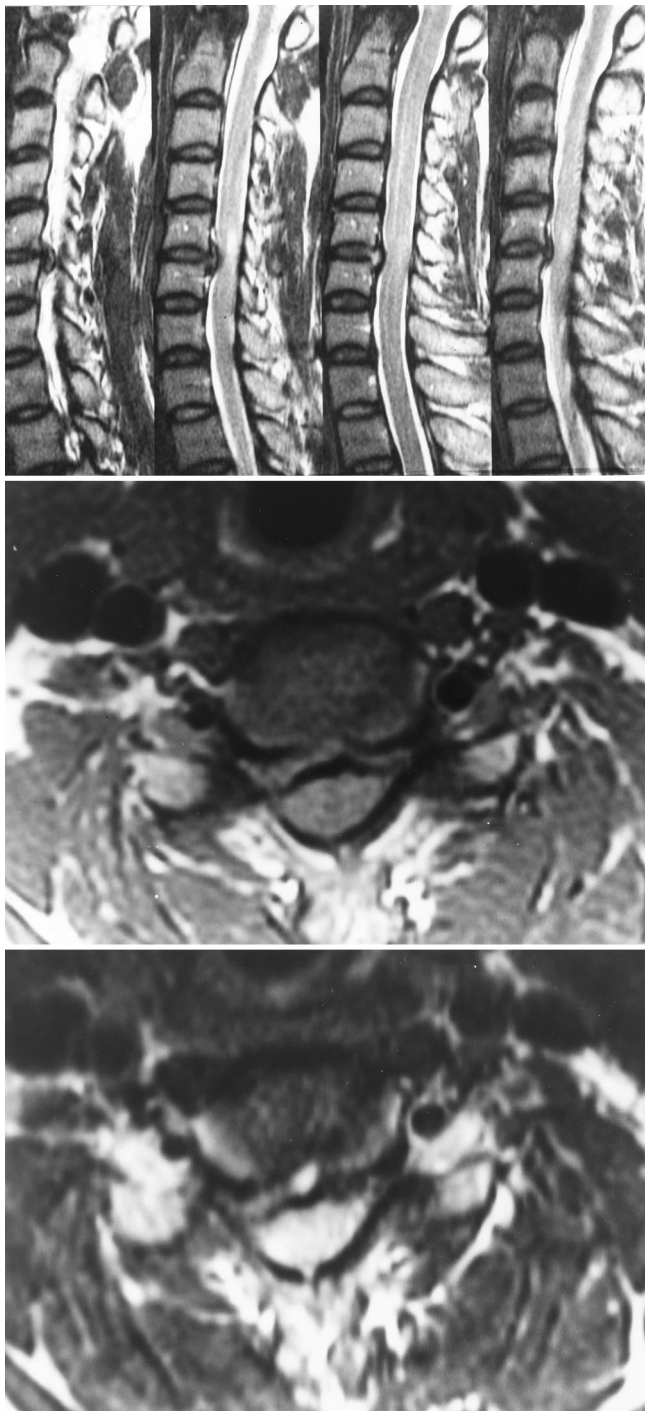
Magnetic resonance imaging studies. *Upper:* Cervical T₂-weighted image demonstrating large disc extrusion, compressed spinal cord, and increased signal intensities in adjacent cord at the C5-6 level. *Center and Lower:* Axial T₁- and T₂-weighted images at the level of C5-6 revealing significant disc extrusion.
